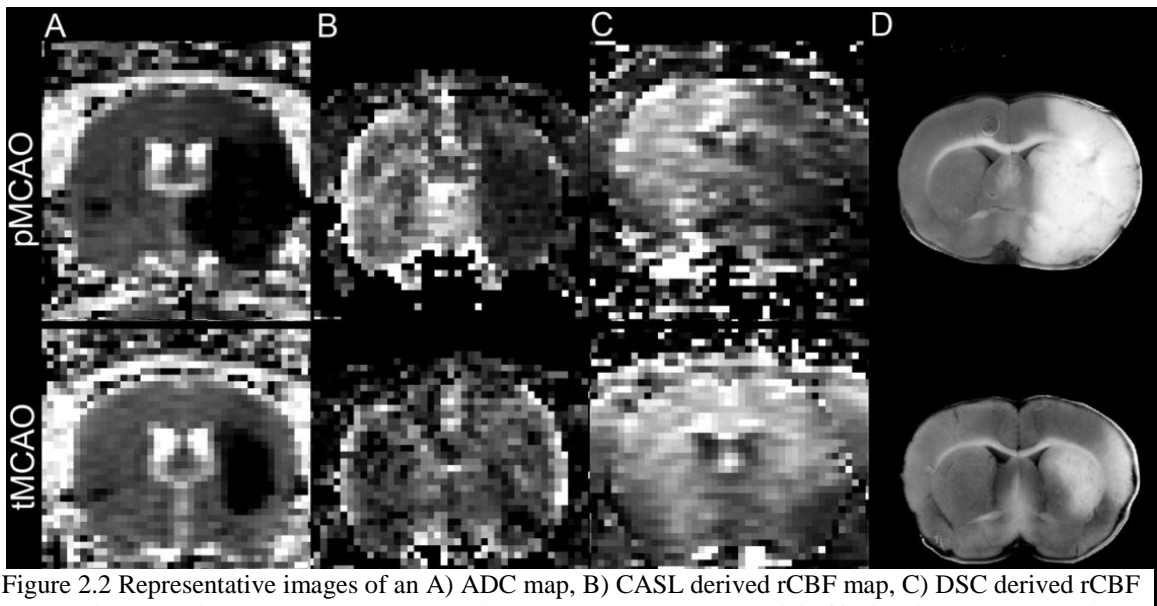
Representative images of an A) ADC map, B) CASL derived rCBF map, C) DSC derived rCBF map, and D) TTC in a pMCAO (top row) and tMCAO (bottom row) model of ischemic stroke. Note that the perfusion-weighted image in the tMCAO model was recorded post reperfusion. All MR images were recorded 90 minutes post MCAO and TTC was performed at 24 hours post MCAO.
